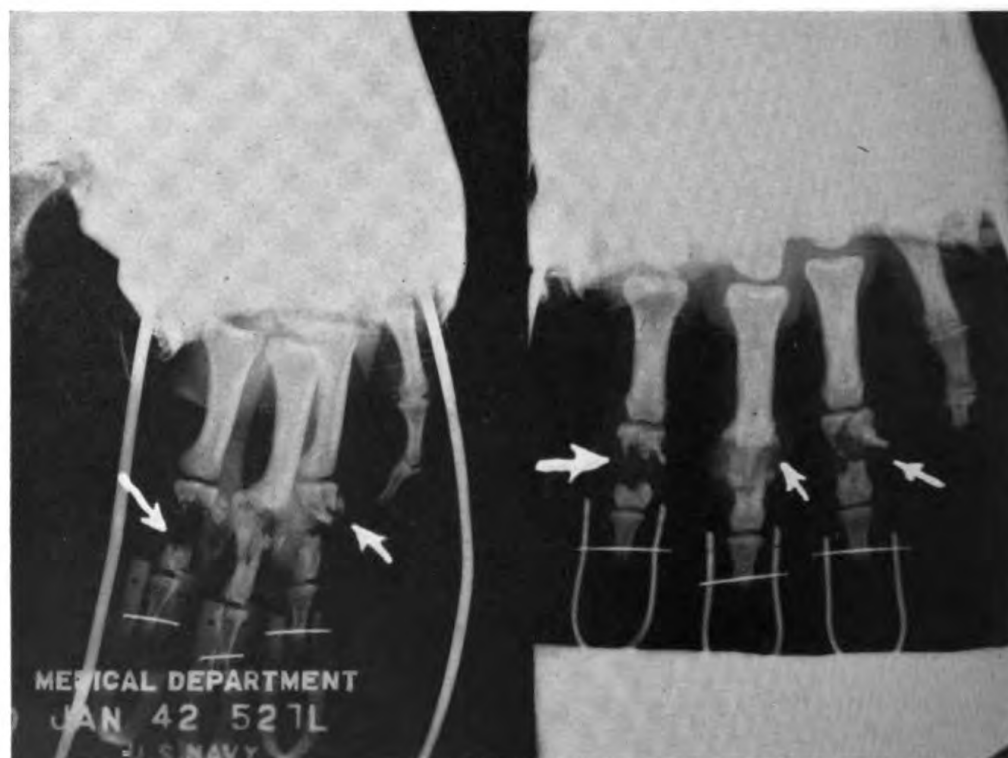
X-RAY IN TRACTION APPLIANCE. WHAT APPEARS TO BE OVEREXTENSION, IS ACTUAL LOSS OF BONE DUE TO INJURY.
